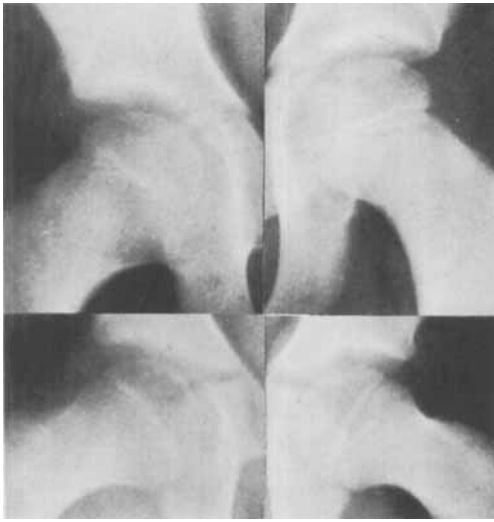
Case 4. Age 8. Radiograph of both hips, showing osteoporosis of the right hip which had been painful for 5 weeks.
